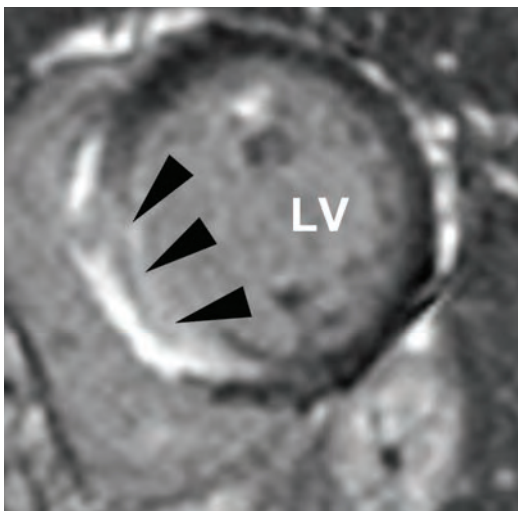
Cardiovascular magnetic resonance images showing the short axis view at the basal myocardial level. There is mid-myocardial and subepicardial late gadolinium enhancement in the interventricular septum (black arrowheads). LV denotes left ventricle.
